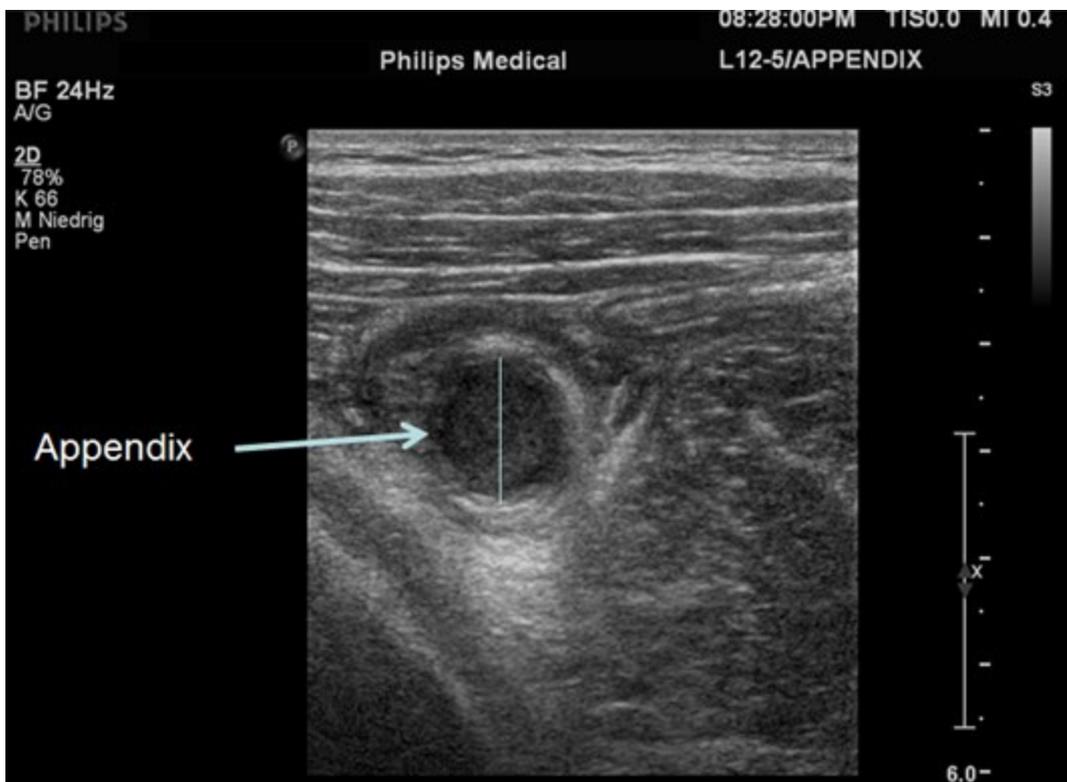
Visible appendix in ultrasound (diameter 15 mm). (Haxhija et al. 2011)
